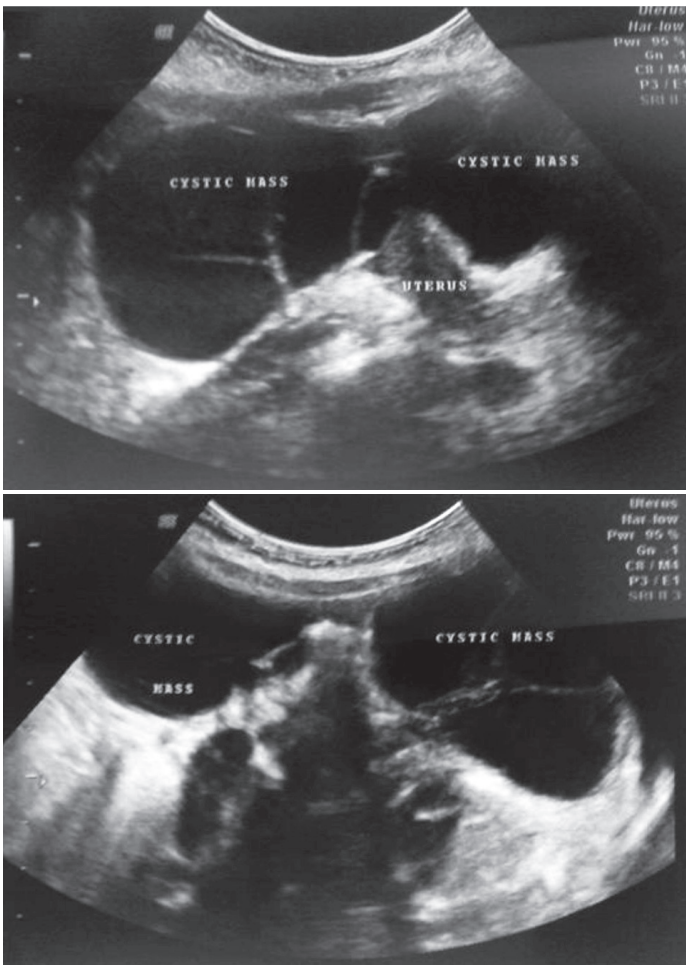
Pelvic ultrasound shows two cystic masses located anterior and superior to the uterus with Cyst 1: unilocular, thin-walled, anechoic, measuring 6.31 x 6.47 x 5.76cm (volume 123.15 cc) and Cyst 2: multilocular (3), Thick walled (0.33 cm), multi-septated (0.16 cm, thin), anechoic, measuring 7.19 x 6.08 x 4.96 cm (volume 113.58 cc). Sassone score of 6.
